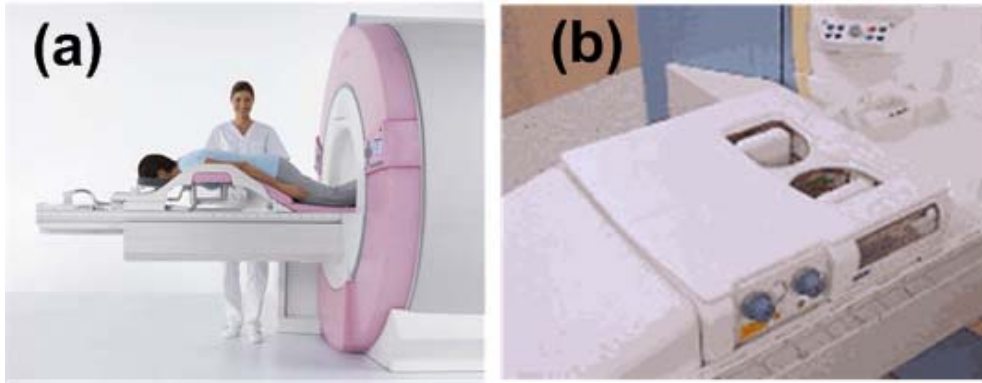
Magnetom Espree-Pink, a 1.5-Tesla MRI dedicated for breast imaging. (a) Instrument overview. (b) Breast array coil for bilateral breast imaging.
